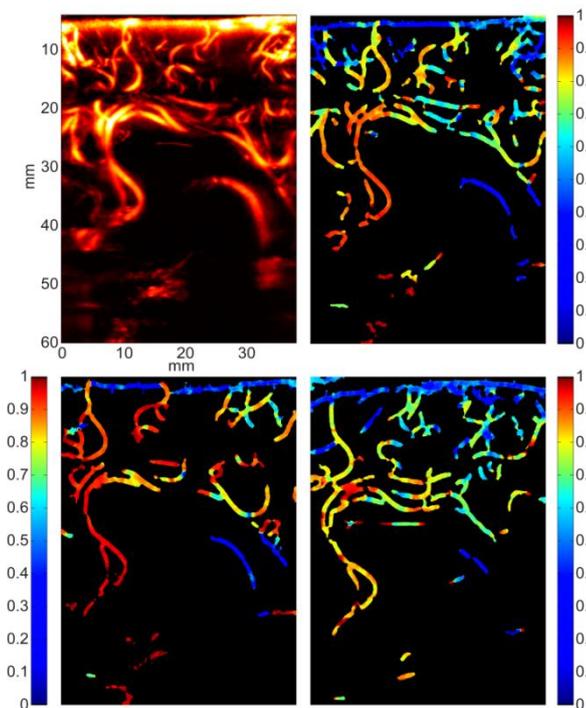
Changes of resistivity observed in the medial sagittal plane of the human newborn brain during a mild fontanelle compression. Top: the Doppler image and its corresponding resistivity m map at baseline without fontanelle compression. (from ref [29])
